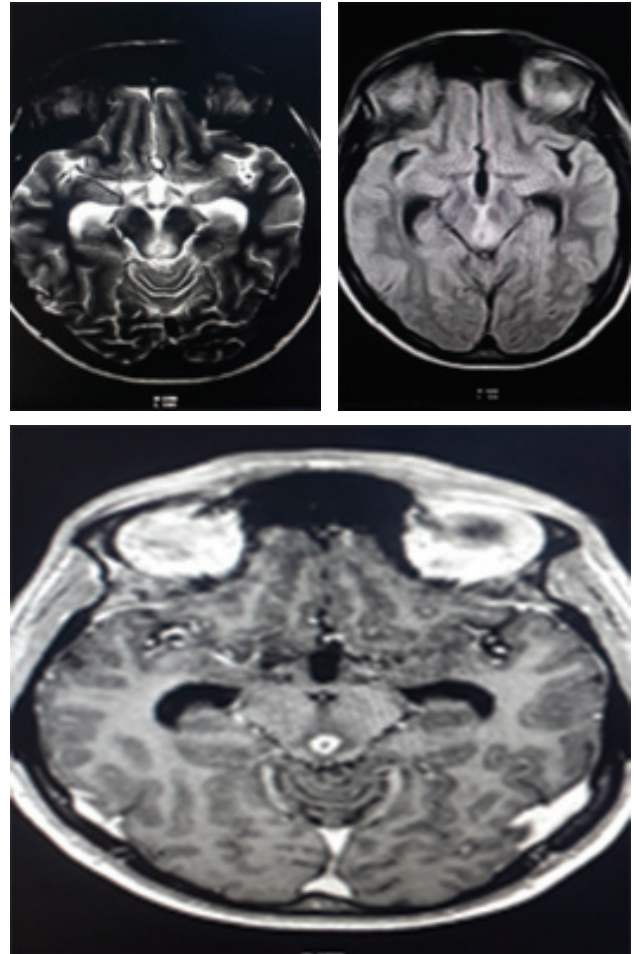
A 34-year-old patient with midline tuberculoma: T2W/FLAIR images show a hypointense granuloma with hyperintense rim in the region of cerebral aqueduct. Post-contrast T1W image shows ring enhancement in post-contrast images. Mild hydrocephalus is seen.
